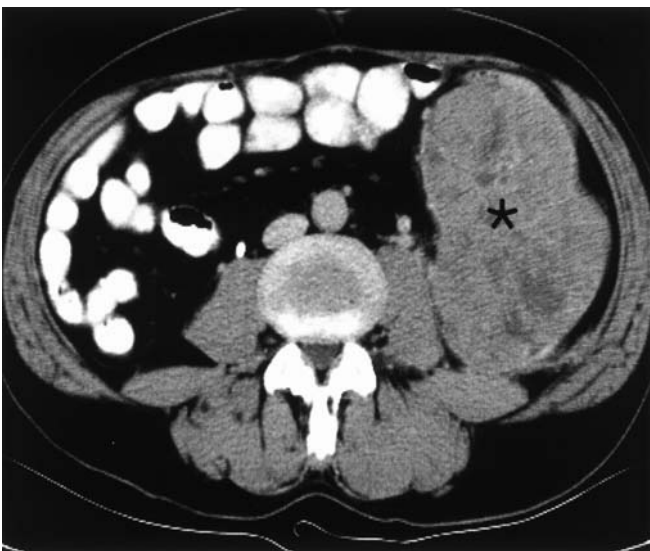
Peritoneal metastasis. The CT scan shows a lobulated mass with central necrotic area in the left lower abdomen (*asterisk*)
